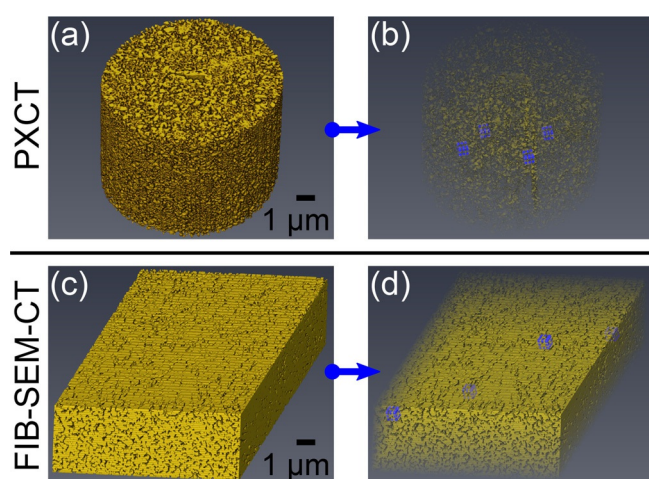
Subvolume extraction showing: (a) PXCT data and (b) selection of four PXCT subvolumes; (c) FIB-SEM-CT data and (d) selection of four FIB-SEM-CT subvolumes. All subvolumes had dimensions of 500×500×500 nm³ and are highlighted in blue, volumes (b) and (d) rendered with transparency.
